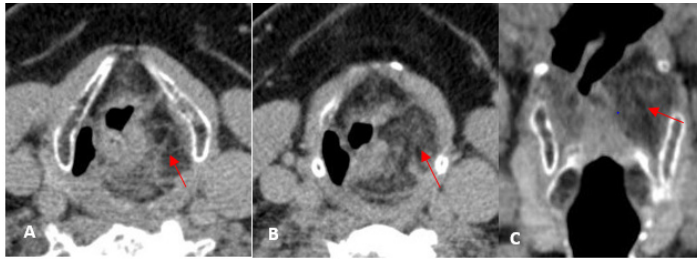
Contrast-enhanced CT of the neck.
